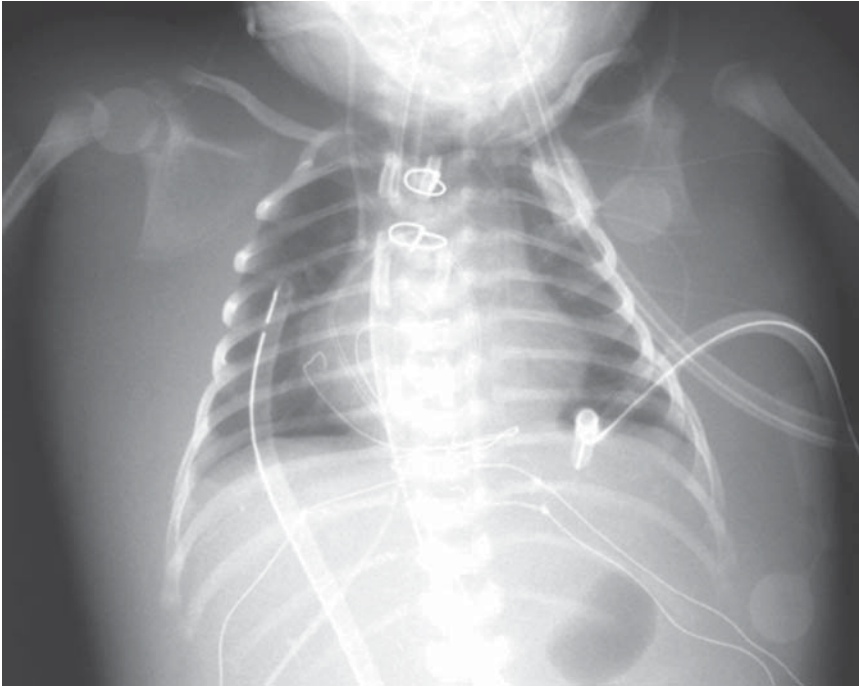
A chest X-ray film on postoperative day 35. Severe subcutaneous edema was seen
